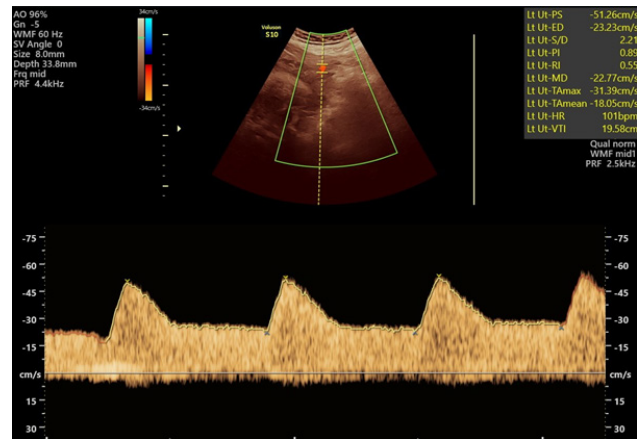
Normal uterine artery Doppler. UTA-PI=0.89, UTA-RI=0.55
